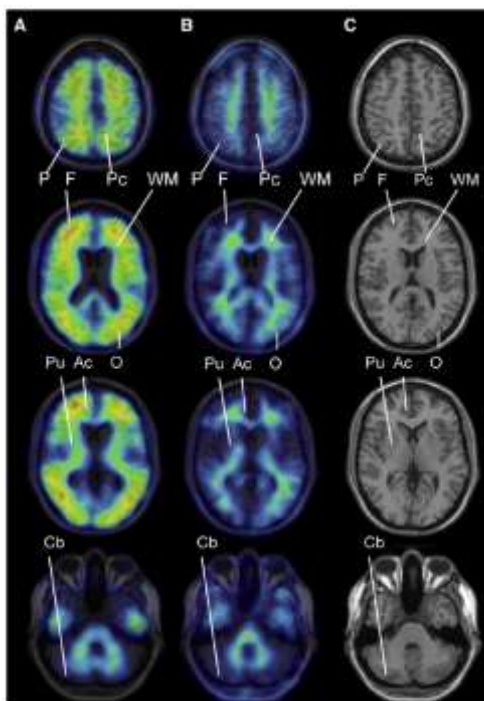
(^{18}F]AV-45) PET images from a patient with Alzheimer's disease (A) and a healthy control (B) taken at 45-55 minutes after tracer injection. All images are superimposed with sample MRI study in Montreal Neurologic Institute space (C) and the intensities were normalized to each cerebellar cortex for comparison.¹⁰⁶
